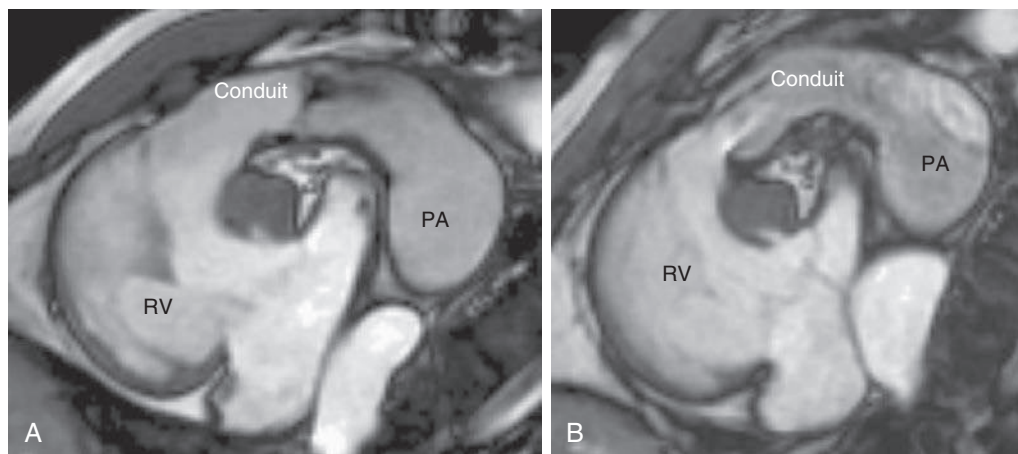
A, Magnetic resonance imaging (MRI) of a patient with dextrocardia and PA with an RV-PA conduit valve that is severely stenosed (black area of turbulence). Note the dilatation of the pulmonary artery confluence distally. B, Repeat MRI in the same patient after surgical replacement of the conduit. There is mild flow acceleration at its proximal anastomosis, but the stenosis is gone. PA, Pulmonary atresia; RV, right ventricle.
